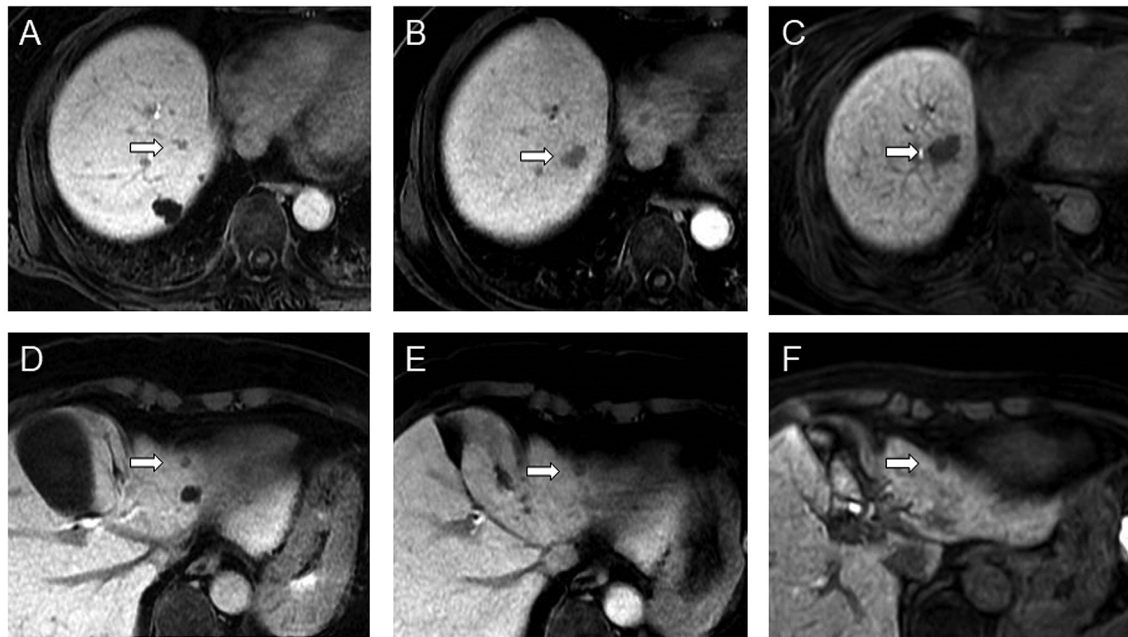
Serial magnetic resonance imaging findings of intrahepatic cholangiocarcinoma and bile duct adenoma. The lesions (arrows) showed hypointensity on axial hepatobiliary phase at the pancreatic neuroendocrine tumor surgery (A and D), and at 22 months (B and E) and 34 months (C and F) after the surgery. Maximal diameters of the bile duct adenoma tumors were 8.4 mm, 9.3 mm, and 10.4 mm, and the intrahepatic cholangiocarcinoma tumors were 6.9 mm, 15.0 mm, and 22.7 mm.
